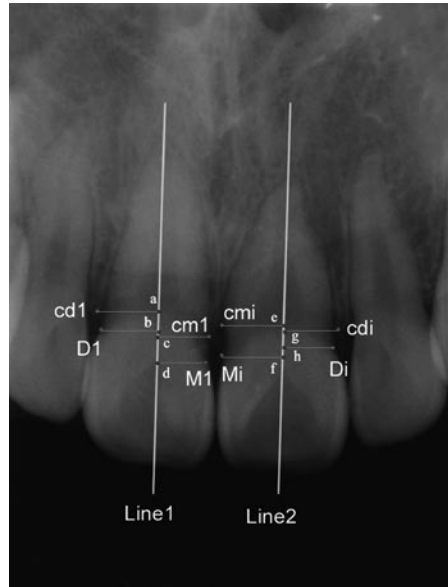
Periapical radiograph of measured bone loss and crown width. Mesial and distal bone losses of the erupted maxillary central incisor = distance between c and d and between a and b, respectively. Mesial and distal bone losses of the extruded maxillary central incisor = distance between e and f and between g and h, respectively. Line 1 and Line 2 = long axes of the erupted and impacted maxillary central incisors, respectively. a = the intersection of cd1 with Line 1. b = the intersection of D1 with Line 1. c = the intersection of cm1 with Line 1. d = the intersection of M1 with Line 1. e = the intersection of cmi with Line 2. f = the intersection of Mi with Line 2. g = the intersection of cdi with Line 2. h = the intersection of Di with Line 2. M1 and D1= mesial and distal cementoenamel junctions, respectively, of the erupted maxillary central incisor. Mi and Di= mesial and distal cementoenamel junctions, respectively, of the extruded maxillary central incisor. cm1 and cd1= mesial and distal crests of the interseptal bone, respectively, of the erupted maxillary central incisor. cmi and cdi= mesial and distal crests of the interseptal bone, respectively, of the extruded maxillary central incisor. Pd and Pm= distal and mesial contours, respectively, of the erupted maxillary central incisor.
